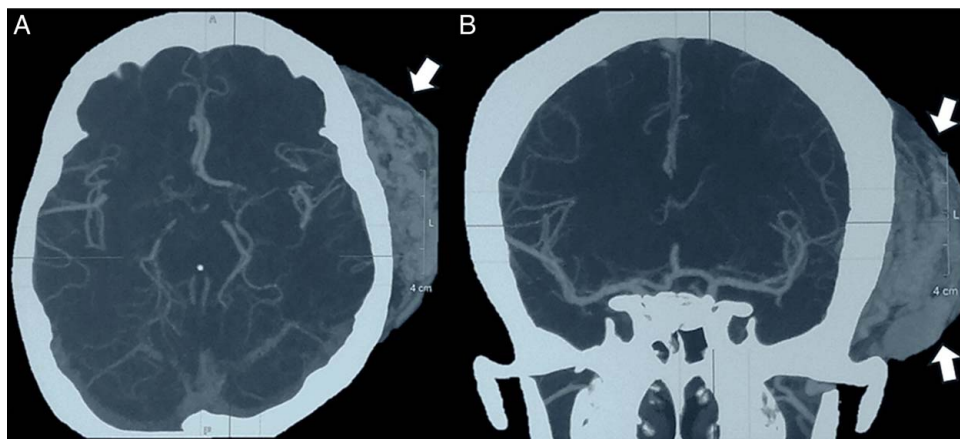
Computed tomography angiogram (CTA) depicting a scalp arteriovenous malformation (white arrows): (A) axial view showing dilated tortuous vascular channels and (B) coronal view confirming the extent and vascular supply of the AVM.
